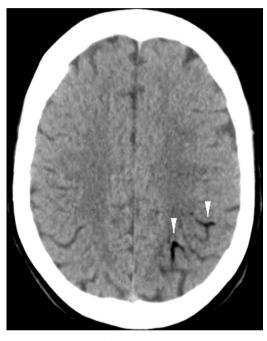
Axial CT of the brain showed gas locules within the left parietal lobe.
